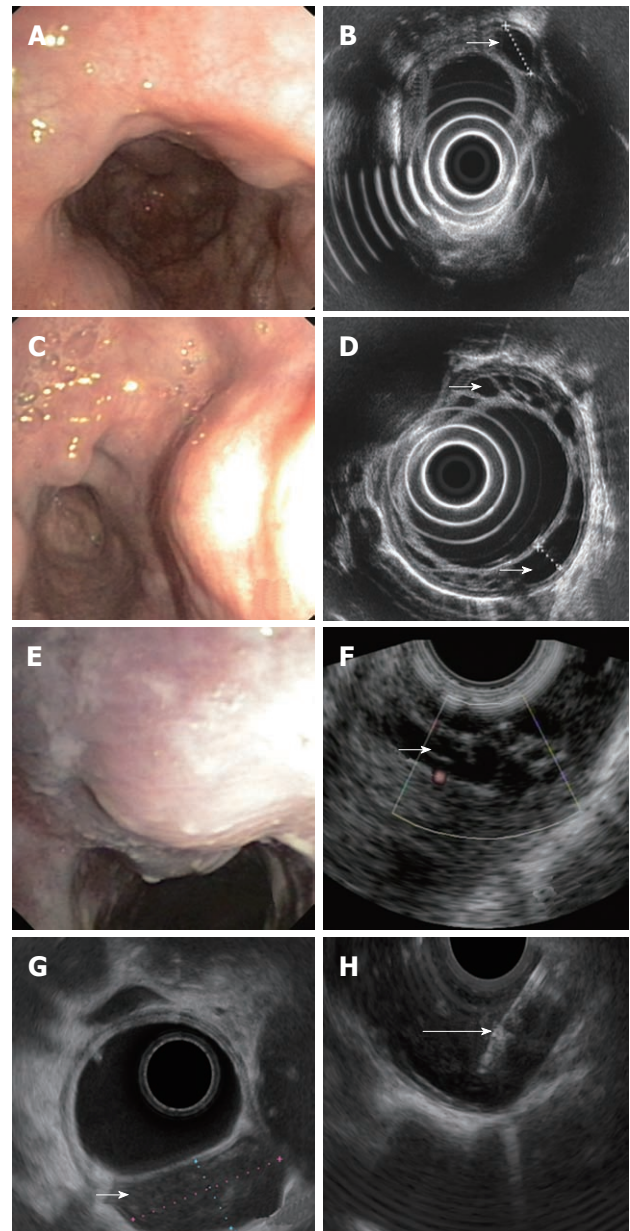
Endoscopic and endosonographic images of described patients. A: Multiple impressions to middle and lower third of esophagus seen in endoscopy; B: Multiple cystic fluid-filled intramural lesions detected on endoscopic ultrasonography (EUS); C: On endoscopy multiple impressions, covered with normal mucosa, localized in the lower third of esophagus; D: On EUS multiple cystic, fluid-filled, intramural lesions; E: Solitary impression, localized 25 cm from the incisor teeth and covered with unchanged mucosa seen in endoscopy; F: On EUS a cluster of anechoic fluid-filled intramural lesions; G: On EUS an anechoic fluid-filled intramural lesion 24 × 12 mm large; H: Aspiration of the fluid with 19G needle. Small arrows show duplication cysts in D, F and G and big arrow shows the biopsy needle in H.
